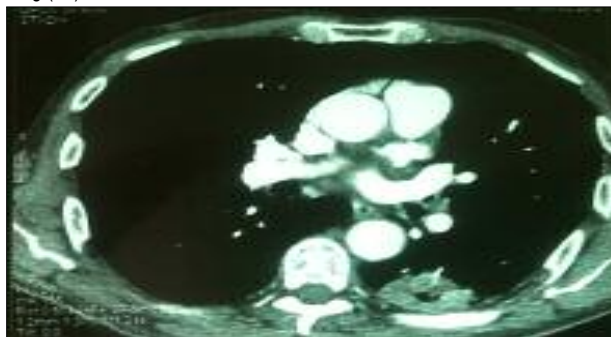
Chest CT scan (mediastinal window): left upper lobe mass of the lung (P4).
